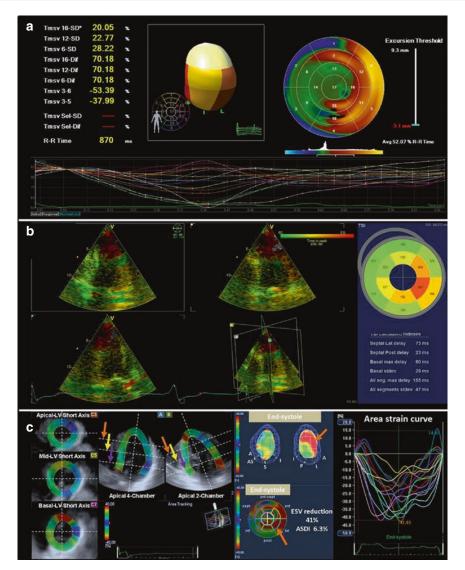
Three-dimensional echocardiographic techniques to evaluate LV dyssynchrony. Panel (a): LV dyssynchrony can be quantified from 3-dimensional full-volume datasets of the left ventricle by measuring the systolic dyssynchrony index (standard deviation of time to minimum systolic volume of 16 subvolumes [Tmsv16-SD]). The LV mechanical dispersion can be also visualized on color-coded polar maps, with the earliest activated regions coded in blue and the latest activated areas coded in orange-red. In this example, the patient shows significant LV dyssynchrony (Tmsv16-SD 20.05%) and the lateral and posterior LV regions as the most delayed activated areas. The time-volume curves of the 16 regional subvolumes are plotted in a graph providing also a visual estimation of LV dyssynchrony. Panel (b): Assessment of LV dyssynchrony with triplane tissue synchronization imaging. The polar map shows the time to peak systolic velocity of 12 basal and midventricular LV
